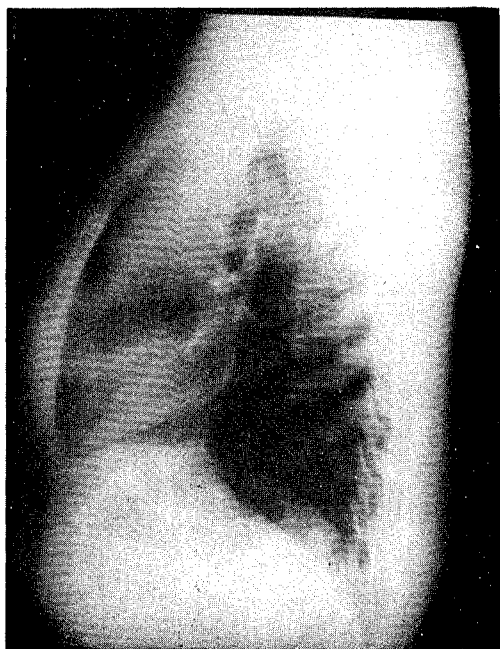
Chest X-ray with appearance suggestive of a mass in the anterior segment of left upper lobe of the lung.
